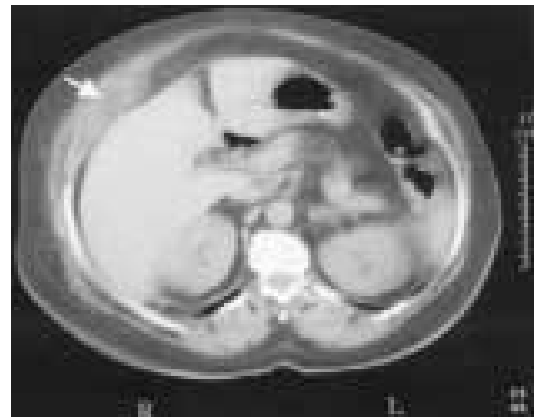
Unenhanced CT scan through upper abdomen demonstrating a mixed fatty density, between the liver and the anterior abdominal wall, with curved linear densities (arrow).
